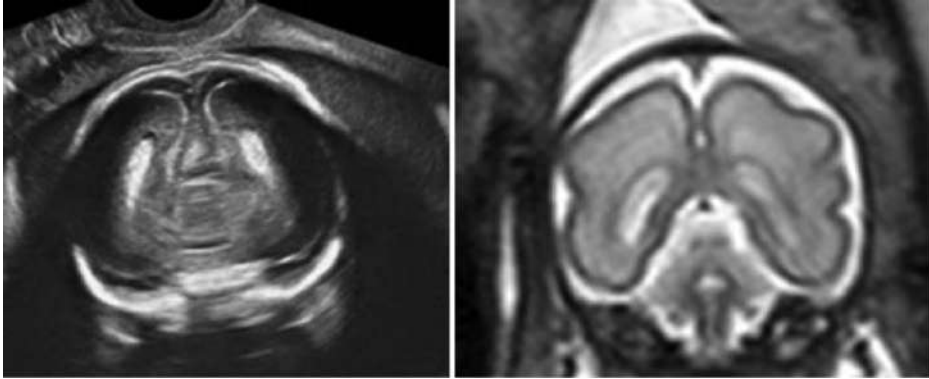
Comparison between fetal acquisitions performed using ultrasound and magnetic resonance respectively.
